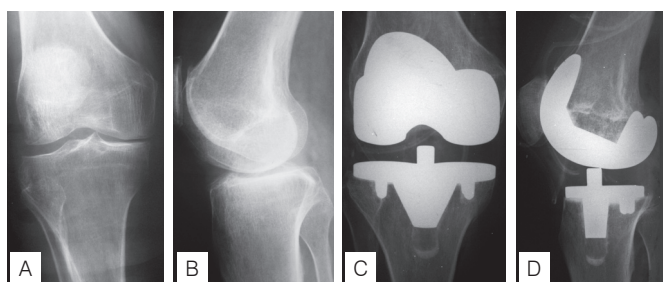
69-year-old female patient, bilateral primary arthrosis with predominant pain on the right. Immediate postoperative radiographies, showing the fitting post of the mobile tibial polyethylene.
